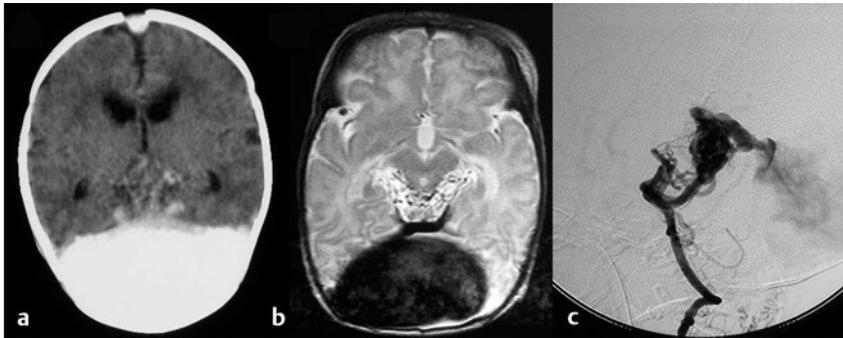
Dural fistula in an infant. The scans show a complex dural fistula in the region of the vein of Galen and torcular in a 3-week-old child with multiple internal and external carotid arterial feeders. (a) Computed tomographic scan of the torcular massively expanded with blood. (b) Similar magnetic resonance image also demonstrates one of the fistulous connections. (c) Angiographic findings of a right vertebral run and one of the fistulas.
